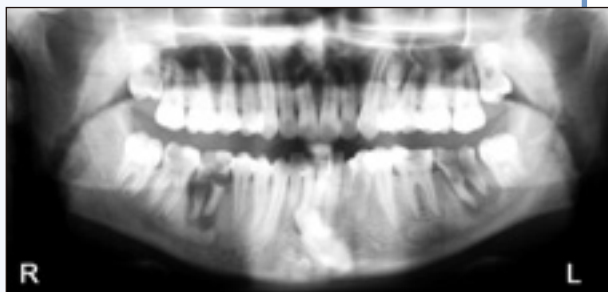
Panoramic radiograph showing impacted tooth 33 that has crossed the midline and is below the apices of the mandibular incisors.
